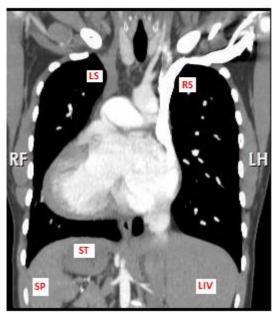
Computed Tomography of thorax and abdomen (Coronal view): LS - Left SVC, RS - Right SVC, ST - Stomach, Liv - Liver, SP - Spleen.
